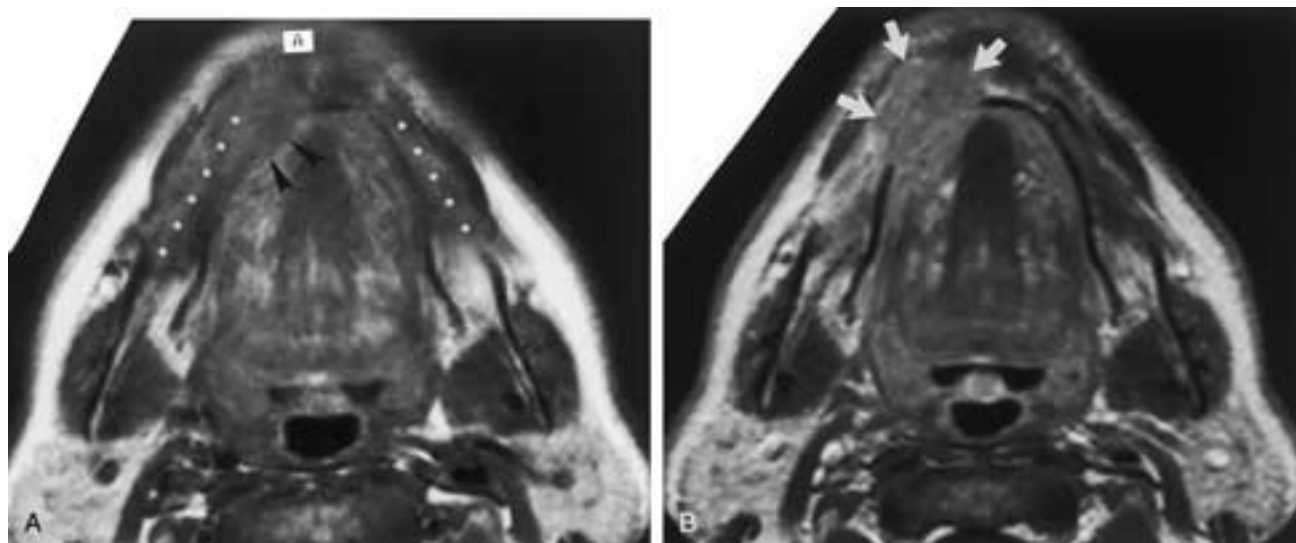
Squamous cell carcinoma of the gingiva-buccal mucosa. Axial T1-weighted MR images without (A) and with (B) contrast enhancement demonstrate a mass involving the anterior aspect of the right mandible. Both the buccal and lingual cortices are destroyed, and tumor extends into the soft tissues of the face anteriorly and into the anterior aspect of the oral tongue posteriorly (black arrowheads in A). The anterior extension is somewhat better defined of the postcontrast image (arrows in B). Separation from the heterogeneous sublingual space is better appreciated on the noncontrast image (arrowheads in A). Extensive replacement of the high-signal marrow within the mandible is best appreciated on the noncontrast image (white dots in A), because the lesion enhances slightly after contrast administration, somewhat obscuring this separation.
